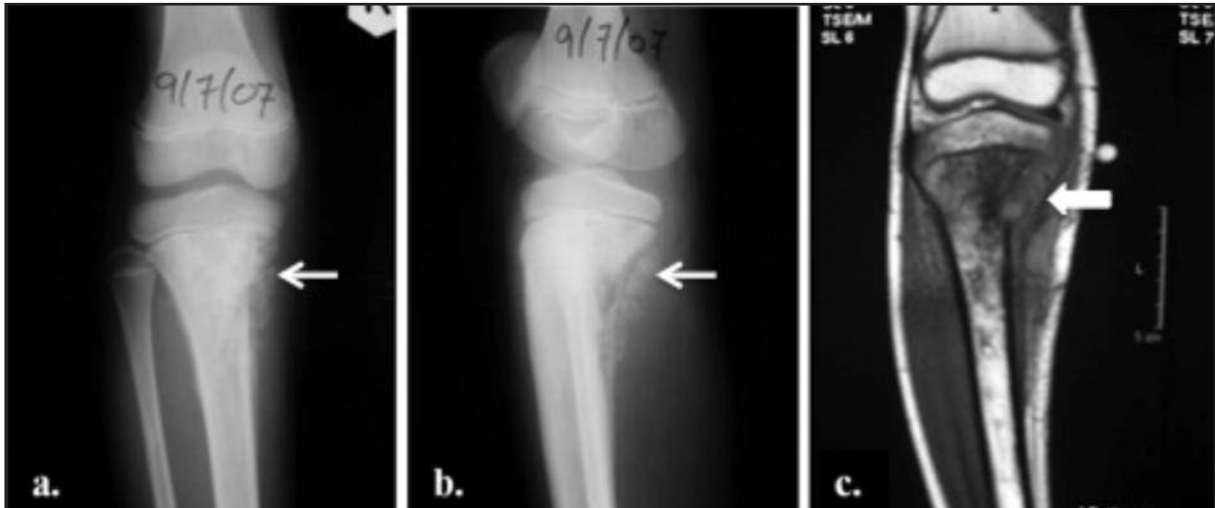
Case 1: Anteroposterior (a) and lateral (b) plain radiographs of the proximal right tibia showing osteolytic lesion involving the metaphyseal region with periosteal reaction (white arrow). Tumour-like osteolytic lesion was seen on MRI (white arrow) (c).
